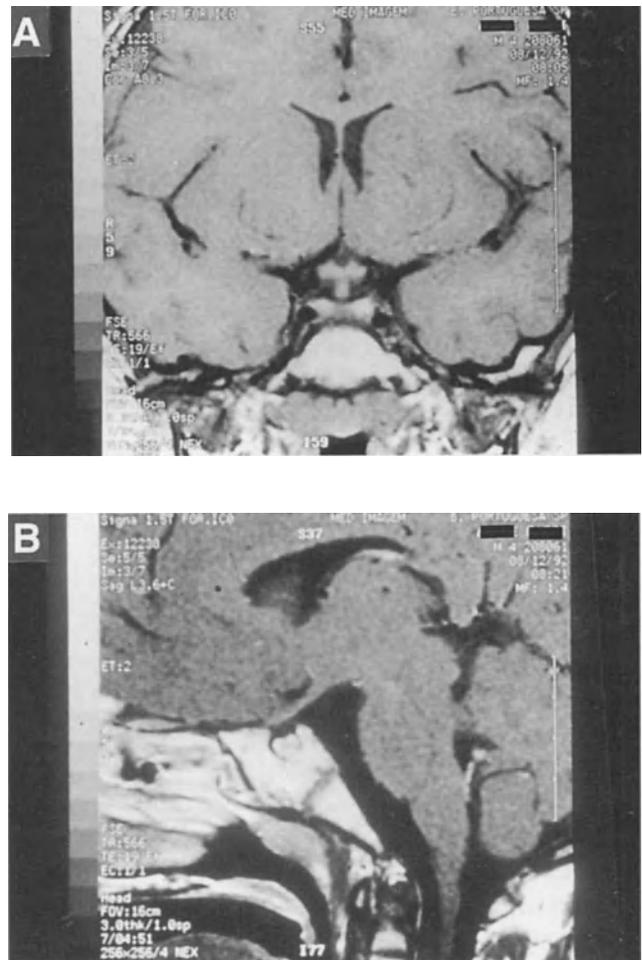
A seven-year-old boy with central diabetes insipidus. (A) MRI coronal view (T1 weighted) showing a thickened stalk. (B) MRI sagittal view (T1 weighted) with disappearance of the typical posterior pituitary signal.
